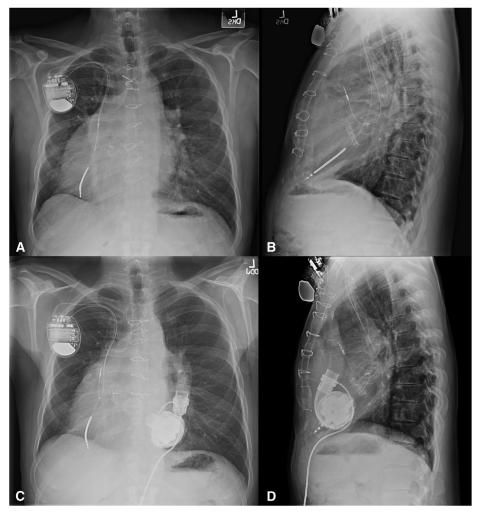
Pre- and postoperative radiographs of HeartMate 3 VAD implantation. A and B, Radiograph of the chest 2 months before VAD implantation. C and D, Radiograph of the chest 3 months post-VAD implantation. Inflow cannula is inserted through the apex of the hypertrophic and dilated systemic right ventricle. The outflow graft was placed intrapericardially to the left side of the heart (in a mirror direction of the usual technique) and anastomosed to the left-side aorta.
